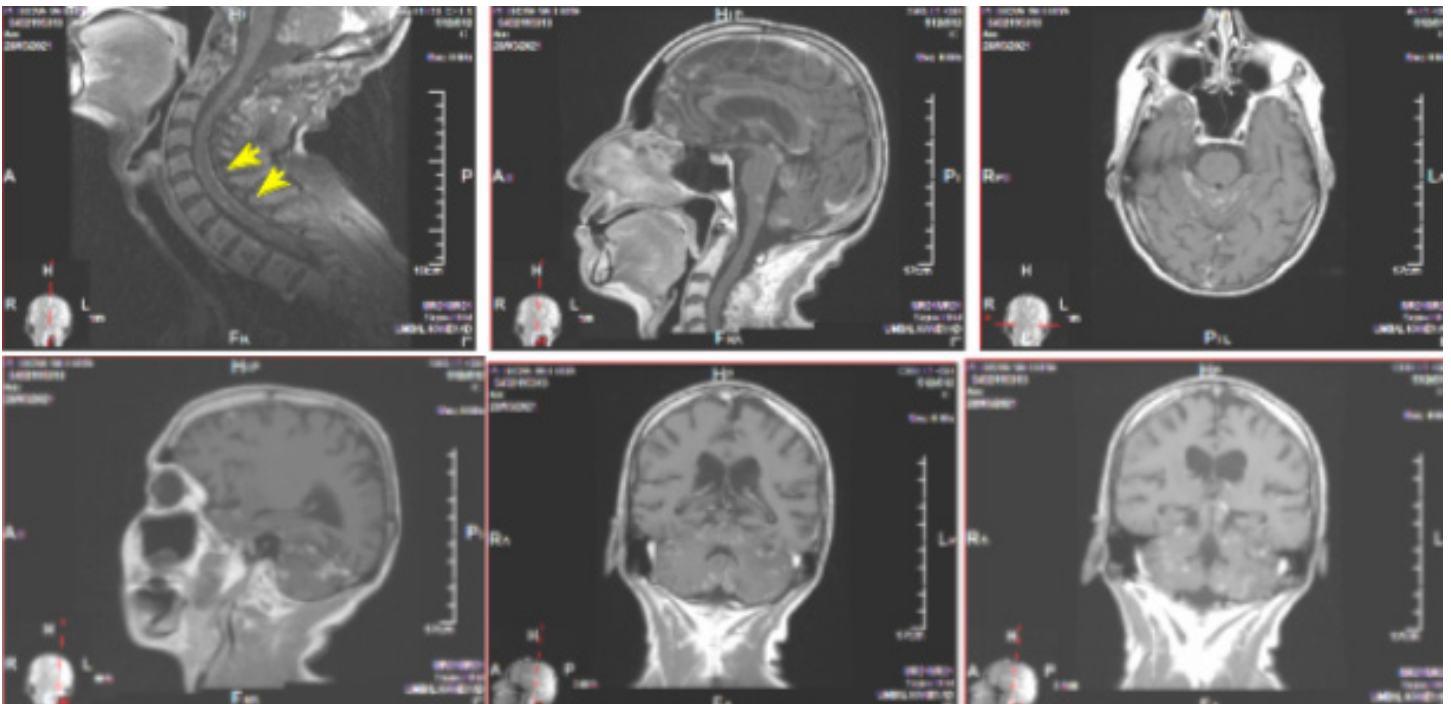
One year after radiotherapy SAG T1 FLAIR MRI, AX T1 FLAIR MRI and COR T1 FLAIR MRI visualized progression of LMD in cerebellum and in cervical part of spinal axis.
